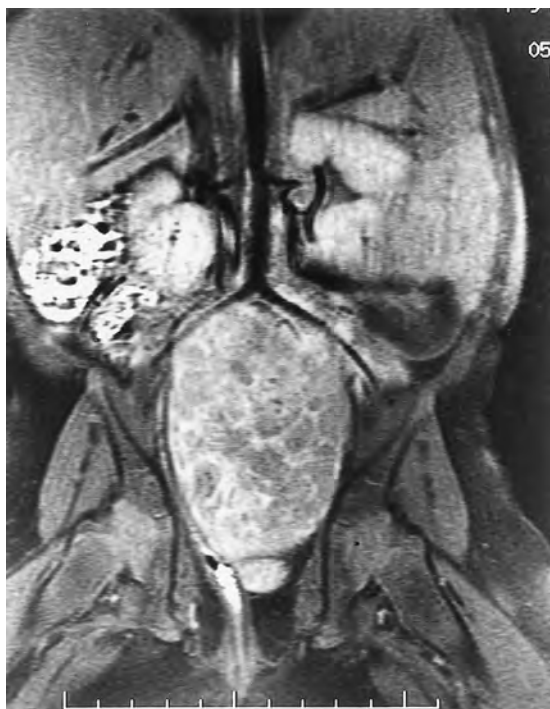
Magnetic resonance image of pelvic neuroblastoma. The bifurcation of the aorta and iliac vessels are well delineated, showing the relationship to the mass.
